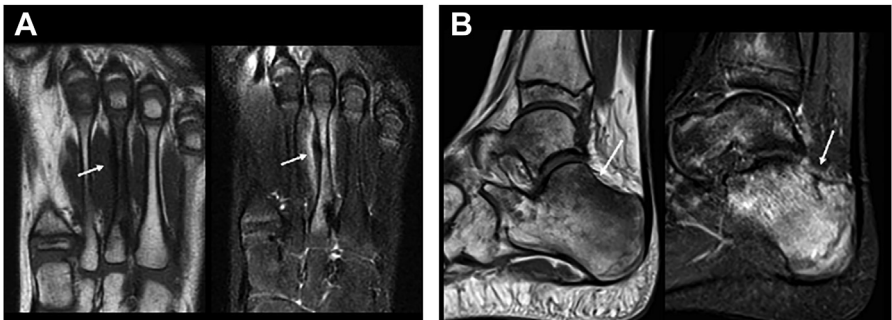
Stress fractures. (A) MRI of the forefoot of a 6-year-old girl with intensive ballet practice and recurrent forefoot pain, without trauma history, showing bone marrow edema, periosteal reaction and a small transverse fracture line on the third metatarsal (*arrow*), compatible with a stress fracture. (B) MRI of the ankle of a 14-year-old boy with hindfoot pain related to soccer practice, showing a line of incomplete fracture involving cortical and medullary bone on the dorsal surface of the calcaneus, perpendicular to the trabecular bone, suggestive of a stress fracture.
